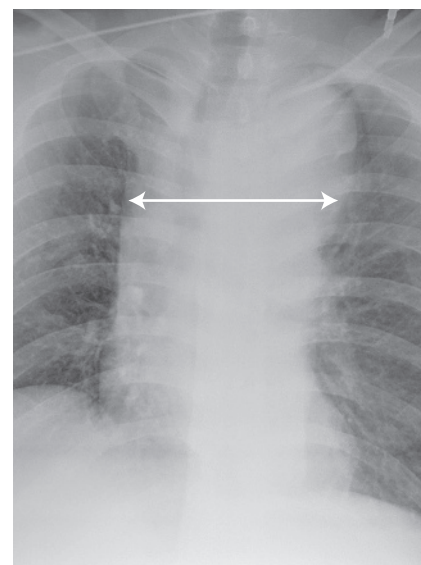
Plain radiograph of the chest following an aortic transection. Note the marked widening of the superior mediastinum (long white arrow) and loss of the normal contours of the aorta.
